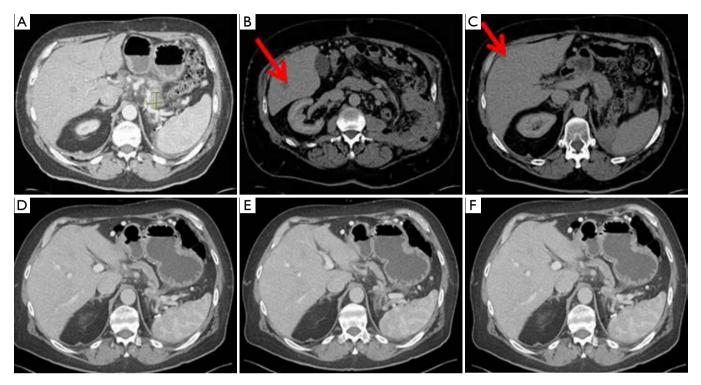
A 66-year-old man diagnosed with biopsy proven oligometastatic pancreas cancer in 2012. CT demonstrates (A) biopsy proven pancreas primary tumor; (B) biopsy proven liver metastasis; (C) 2nd liver metastasis. Patient was treated with gemcitabine and abraxane followed by 5-FU, leucovorin, oxaliplatin, and irinotecan. Twenty-four months after diagnosis, CT demonstrated significant radiologic response in (D) pancreas primary; (E) liver metastasis; and (F) 2nd liver metastasis. Surgical resection of pancreas and liver lesions demonstrated complete pathologic response in all three sites and patient currently has no evidence of disease 6 months post resection and 30 months after diagnosis. CT, computed tomography; 5-FU, 5-fluorouracil.
